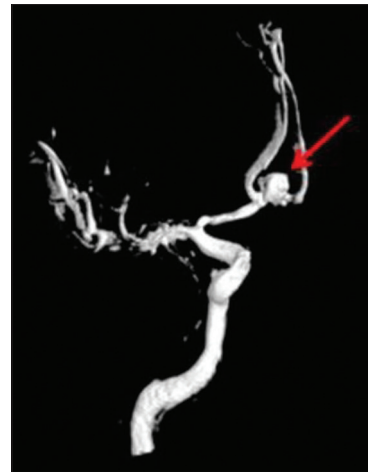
Three-dimensional computed tomographic angiographic view of intracranial aneurysm of the anterior cerebral artery
